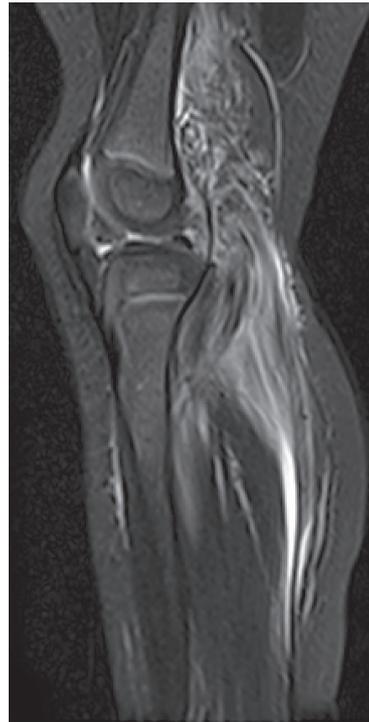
Sagittal T2-weighted fat-suppressed MR image of the right leg. High signal intensity extended from the lower leg to the femur, suggesting the presence of inflammation spreading towards the proximal region.
